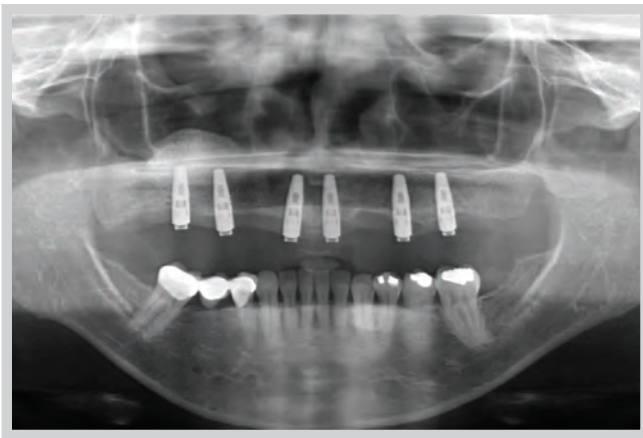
Panoramic radiographic view of the pretreatment condition.
